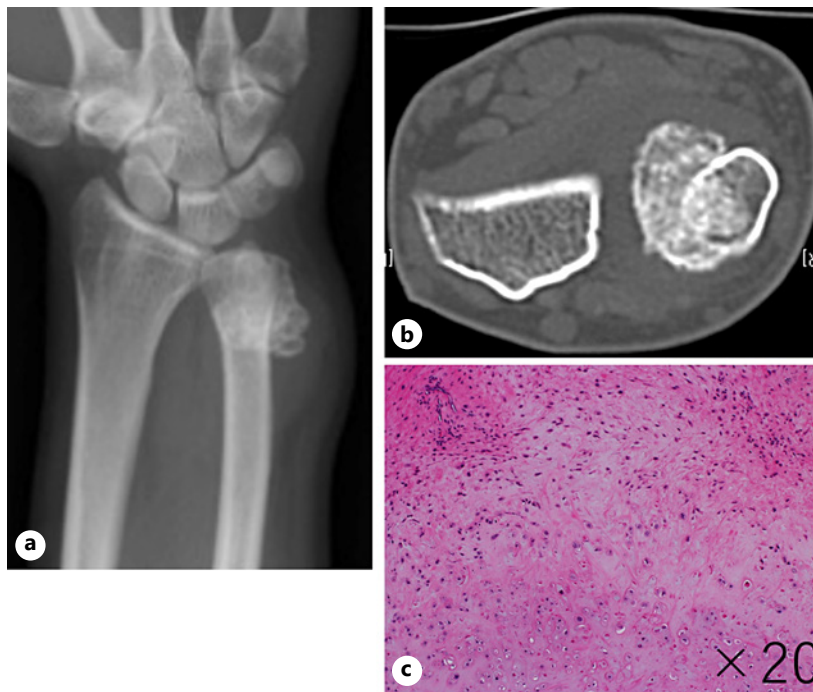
Radiological findings at initial presentation. a X-ray showed a 2-cm densely ossified lesion with a multilobular surface in the distal ulna. b CT showed a bone-forming lesion in the left distal ulna infiltrating intramedullary cancellous bone and developing to an extracortical mass. c Excisional biopsy showed proliferated woven bone and small numbers of atypical tumor cells.
